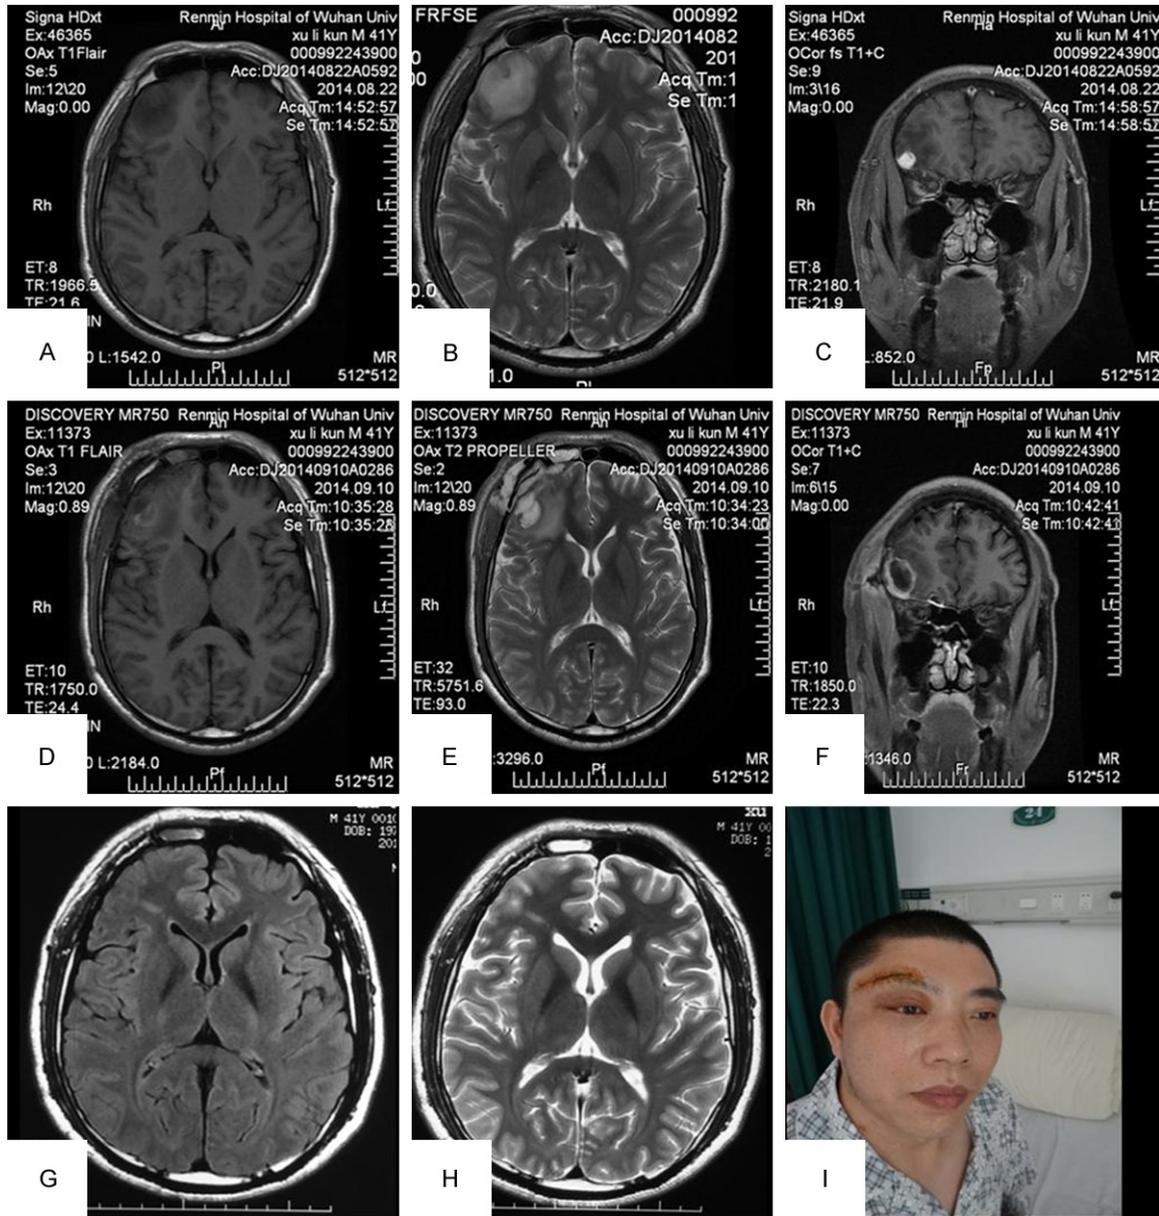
Brain magnetic resonance imaging (MRI) scans of the patient. A: Non-contrast-enhanced, T1-weighted image showed a round mass-like lesion with hypointensity in the right frontal lobe. B: T2-weighted images demonstrated severe cerebral edema around the enhancing mass. C: Contrast-enhanced T1-weighted coronal image revealed a mass adjacent to the enhanced dura over the cerebral convexity. D-F: 2 weeks after operation, the postoperative MRI scans showed that the enhancing mass in the right frontal region had disappeared. G, H: Three months after operation, the postoperative MRI scans showed that edema around the enhancing mass had also disappeared. I: The incision of supraorbital keyhole approach.
